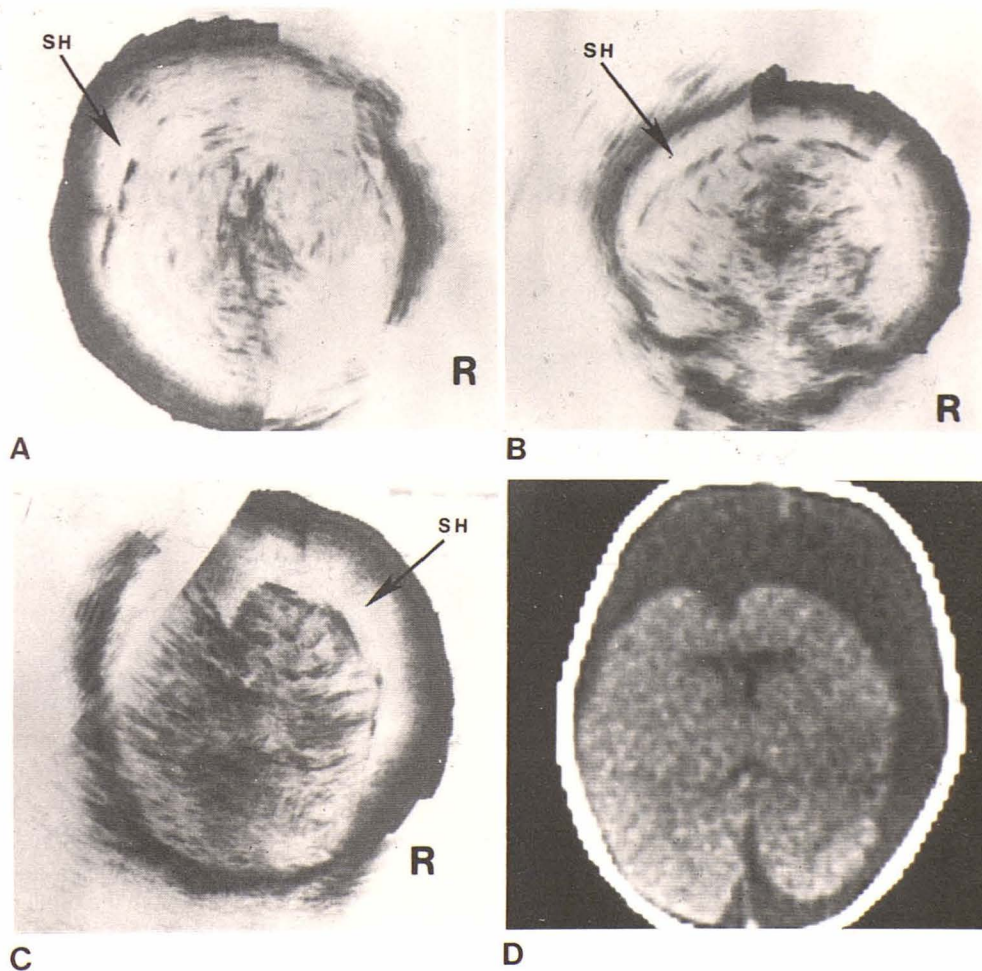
Case 9. Subdural hematoma in 3-week-old infant with birth history of difficult, traumatic forceps delivery and right parietal cephalohematoma. She did well at home until seizures developed at age 3 weeks. Axial (A) and coronal (B) scans. Large bilateral subdural fluid collections (SH) and subdural taps yielded bloody fluid. Subdural hematomas repeatedly tapped but reaccumulated and enlarged on axial ultrasound scan (C) and CT scan (D). (Case 9 seen after original 111 patients.)
